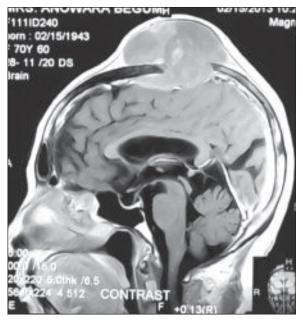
Contrast MRI of brain showing both intra and extra cranial extension of tumor with dural attachment.
